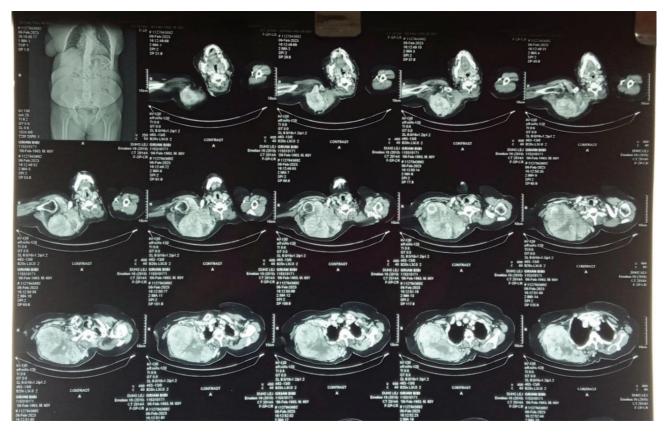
CT scan showing heterogeneously enhancing mass lesion in the right scapular region destroying the glenoid cavity along with the involvement of various muscles.
